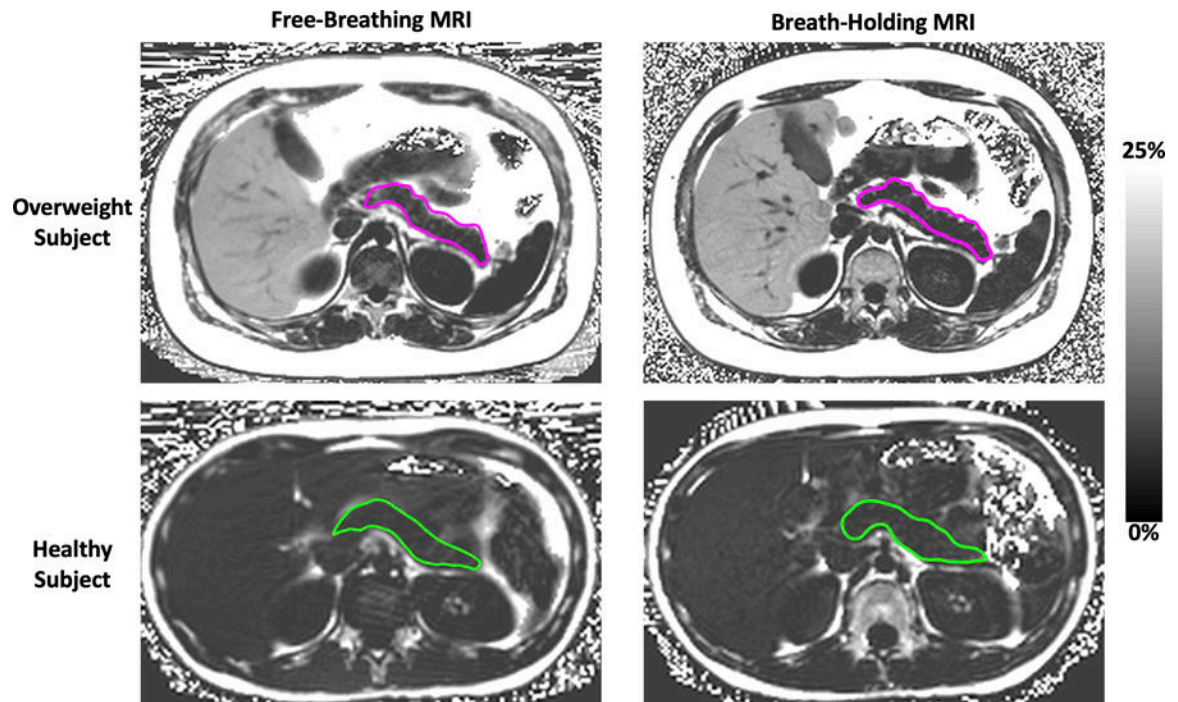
Free-Breathing vs. Breath-Holding MRI PDFF Maps With Pancreatic Contours. Top row shows FB- and BH-MRI PDFF maps from a single overweight subject (12 years old, male, BMI = 29.0 kg/m²). Bottom row shows FB- and BH-MRI PDFF maps from a single healthy subject (14 years old, male, BMI = 18.4 kg/m²).
